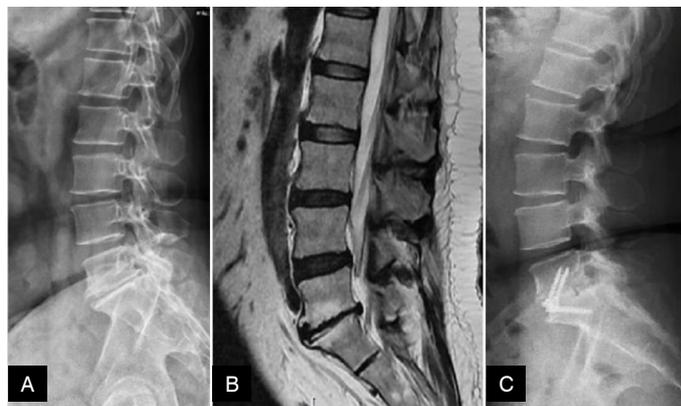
A: Preoperative radiograph of ALIF L5-S1; B: Sagittal T2-weighted MRI of the lumbosacral spine showing L5-S1 degenerative discopathy with disc protrusion; C: Postoperative radiograph of ALIF L5-S1.
